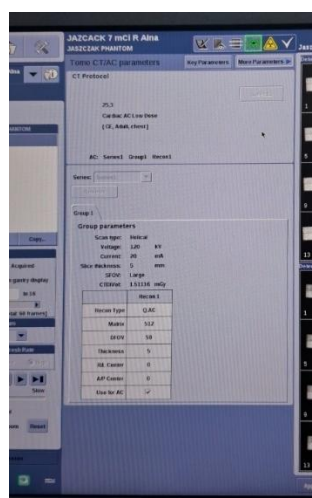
CT parameter acquisition
